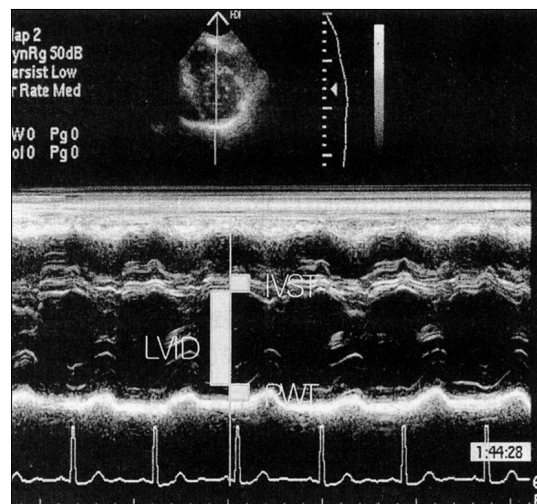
Echocardiographic measurement of LV mass using M-mode technique. LV mass (g) = $0.80 \{ 1.04 [(IST + PWT + LVID)^3 - (LVID)^3] \} + 0.6$. IST : interventricular septal thickness, PWT : posterior wall thickness, LVID : left ventricular internal diameter.
